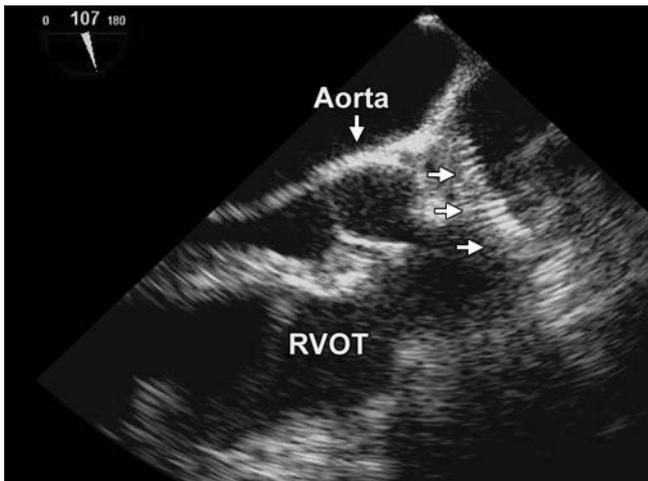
Intraoperative transesophageal echocardiogram of the right ventricular outflow tract.
